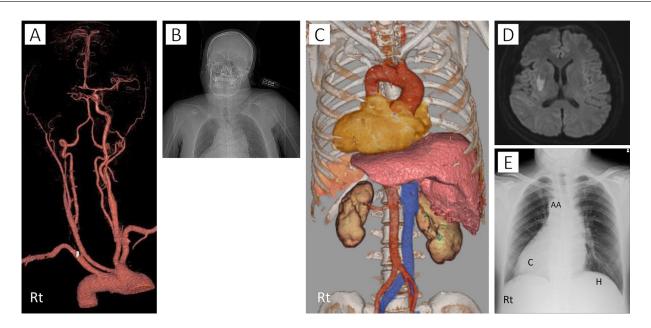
Imaging examinations of the patient reported in this case. (A) Head and neck computed tomography (CT) angiography showing right internal carotid artery occlusion. (B) CT scout view showing dextrocardia. (C) Chest and abdominal CT confirmed situs inversus. (D) Diffusion-weighted imaging on the day after mechanical thrombectomy showing acute infarction in right putamen. (E) Chest X-ray reveals cardiac apex (C) and aortic arch (AA) on the right side with an elevated hemidiaphragm (H) on the left side.
